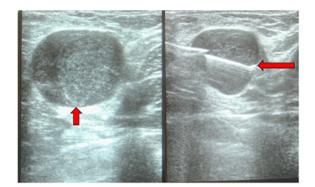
B mode ultrasound of the left axillary lymph node (short arrow) with core biopsy needle (long arrow) seen within it.
